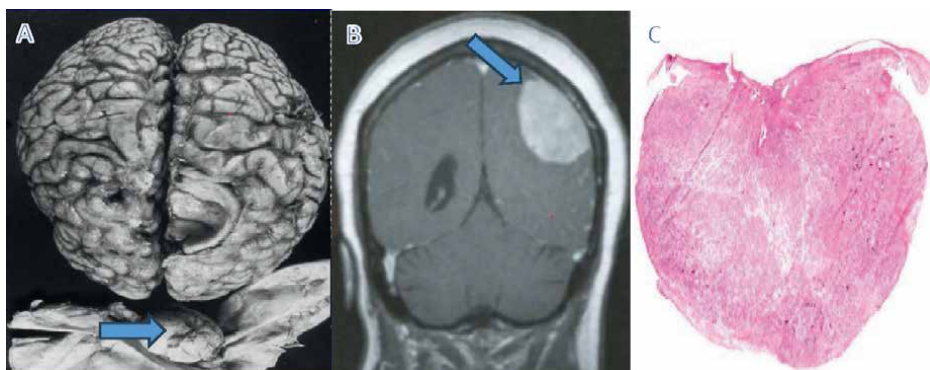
Incidental finding of a meningioma during autopsy, arrow (A), tumor made a dent in brain tissue. (B) CT scan of a left frontal meningioma, the arrow indicates the dural tail. The tumor had mass effect to push the lateral ventricle. A gross picture of a resected meningioma attached to the dura (C).*
